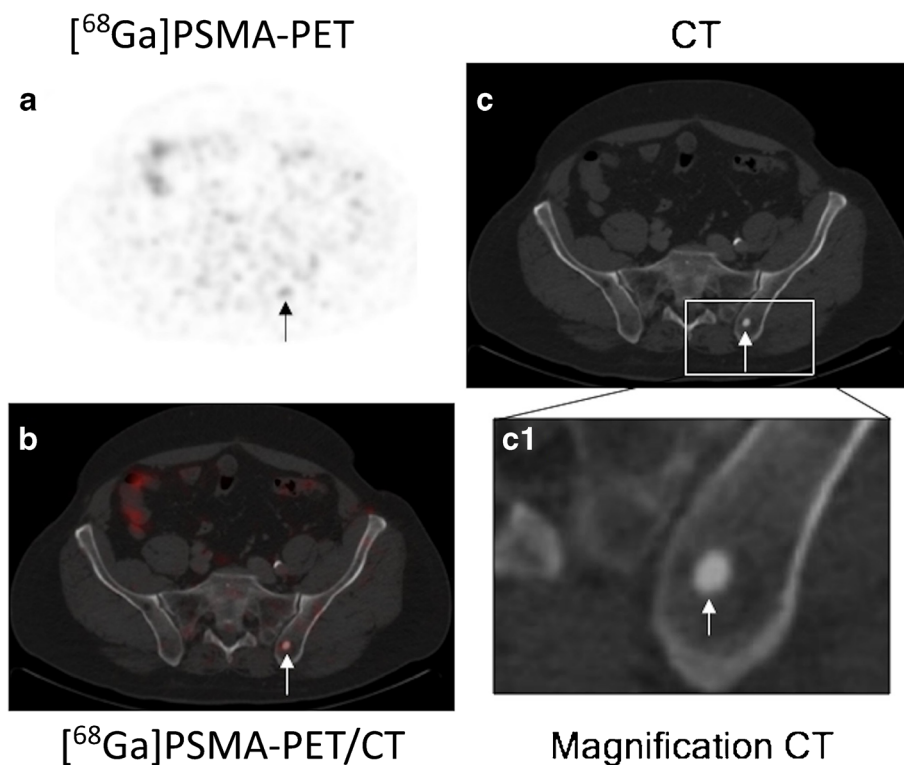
Example of an osteoblastic bone metastasis in the left Os ilium with a relatively low $[^{68}\text{Ga}]\text{PSMA-HBED-CC}$ uptake. Example of patient with a focal osteoblastic metastasis (*arrow*) in the dorsal part of the left Os ilium. a In the $[^{68}\text{Ga}]\text{PSMA PET}$, only a relatively low $[^{68}\text{Ga}]\text{PSMA}$ uptake can be visualized. b In the fused $[^{68}\text{Ga}]\text{PSMA PET/CT}$ image, the low uptake of the tracer colocalizes with an osteoblastic metastasis. The SUV_{max} of the bone metastasis was 3.0, and the HU_{mean} was 455. c On the CT image, the focal osteoblastic metastasis can be clearly visualized (magnification in c1). The BVC evaluation was based on a follow-up $[^{99\text{m}}\text{Tc}]\text{DPD-SPECT}$ and rising PSA levels. Five further osseous metastases were detected in this patient.
